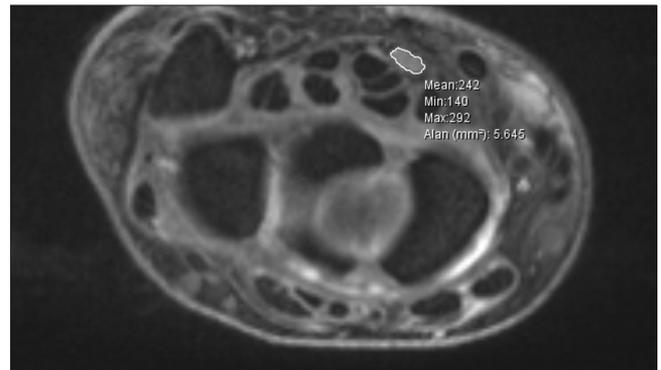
An example of the measurement of the cross-sectional area of median nerve on axial T2-weighted magnetic resonance imaging.
